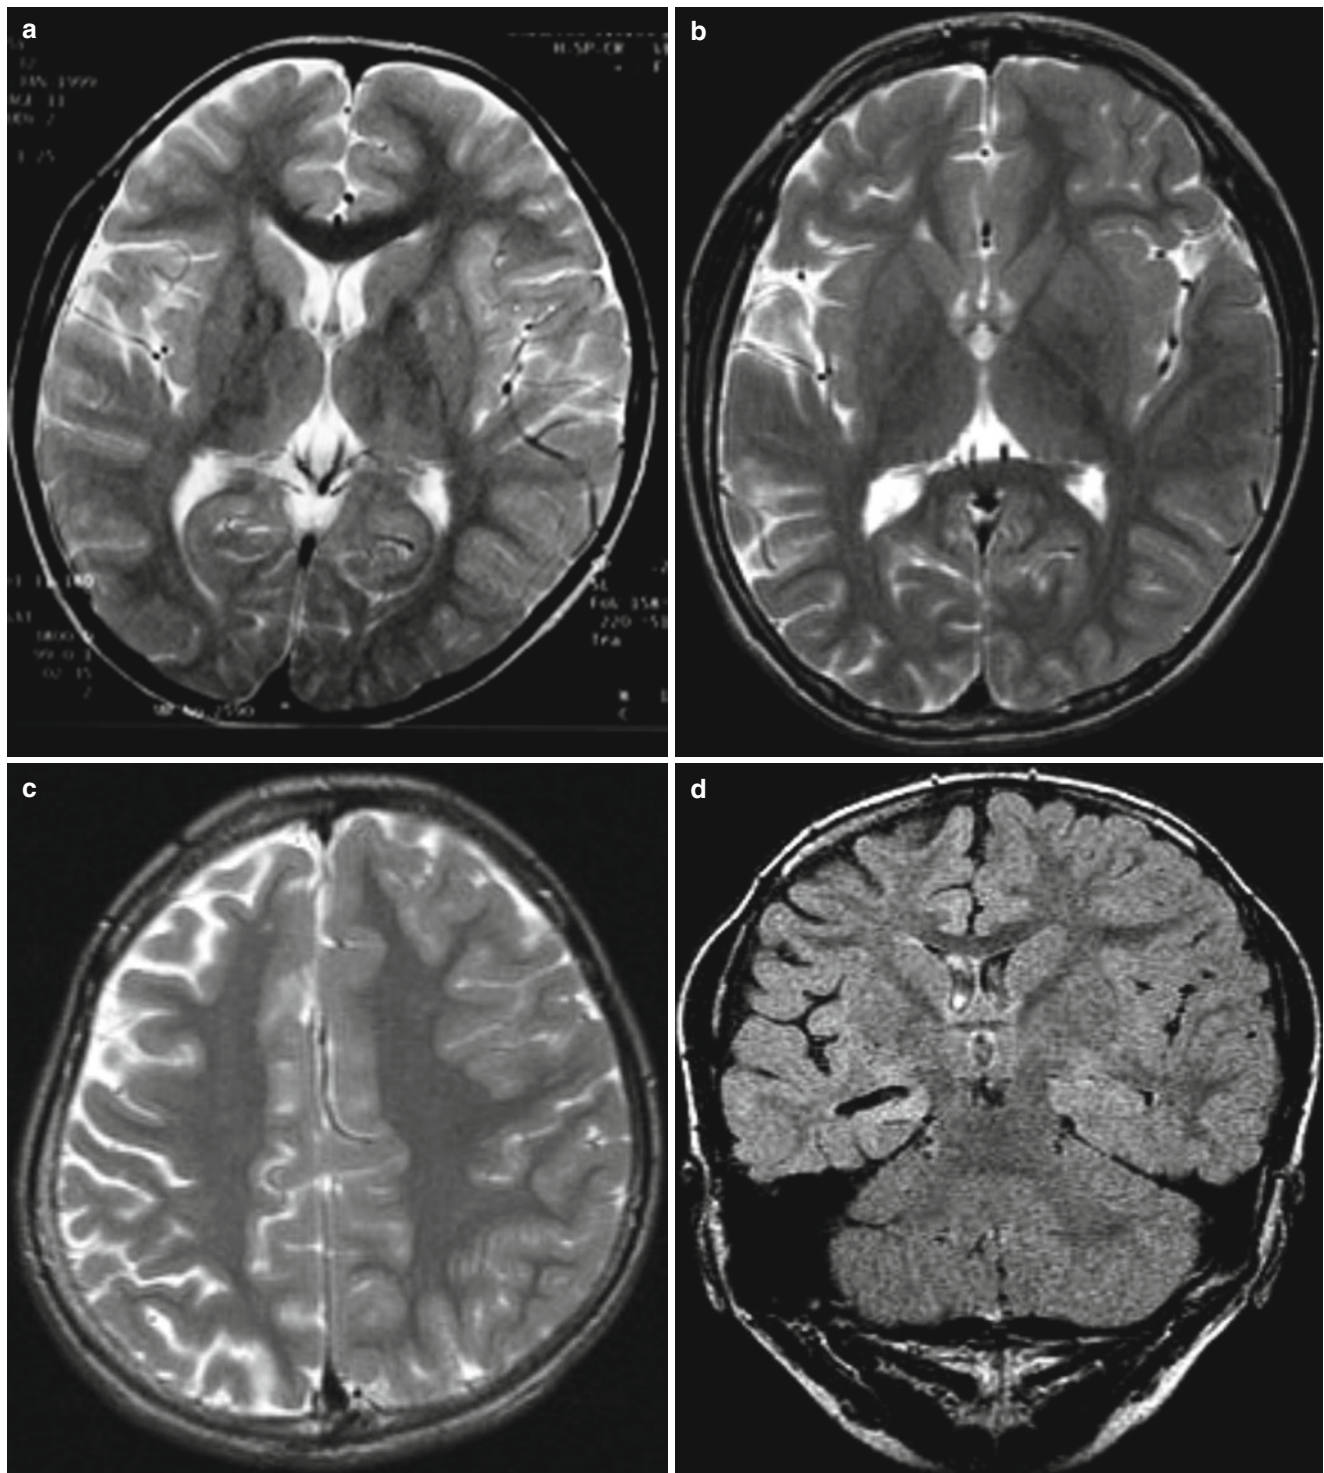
Rasmussen encephalitis in a 7-year-old boy. (a) Initial MR image shows no remarkable abnormalities in the brain. (b, c) 2-year follow-up image shows unilateral right hemispheric atrophy without
